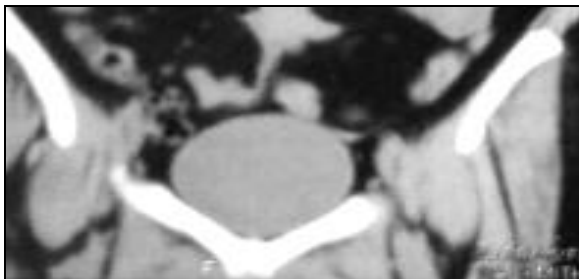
Emphysematous cystitis resolved (computed tomography)
